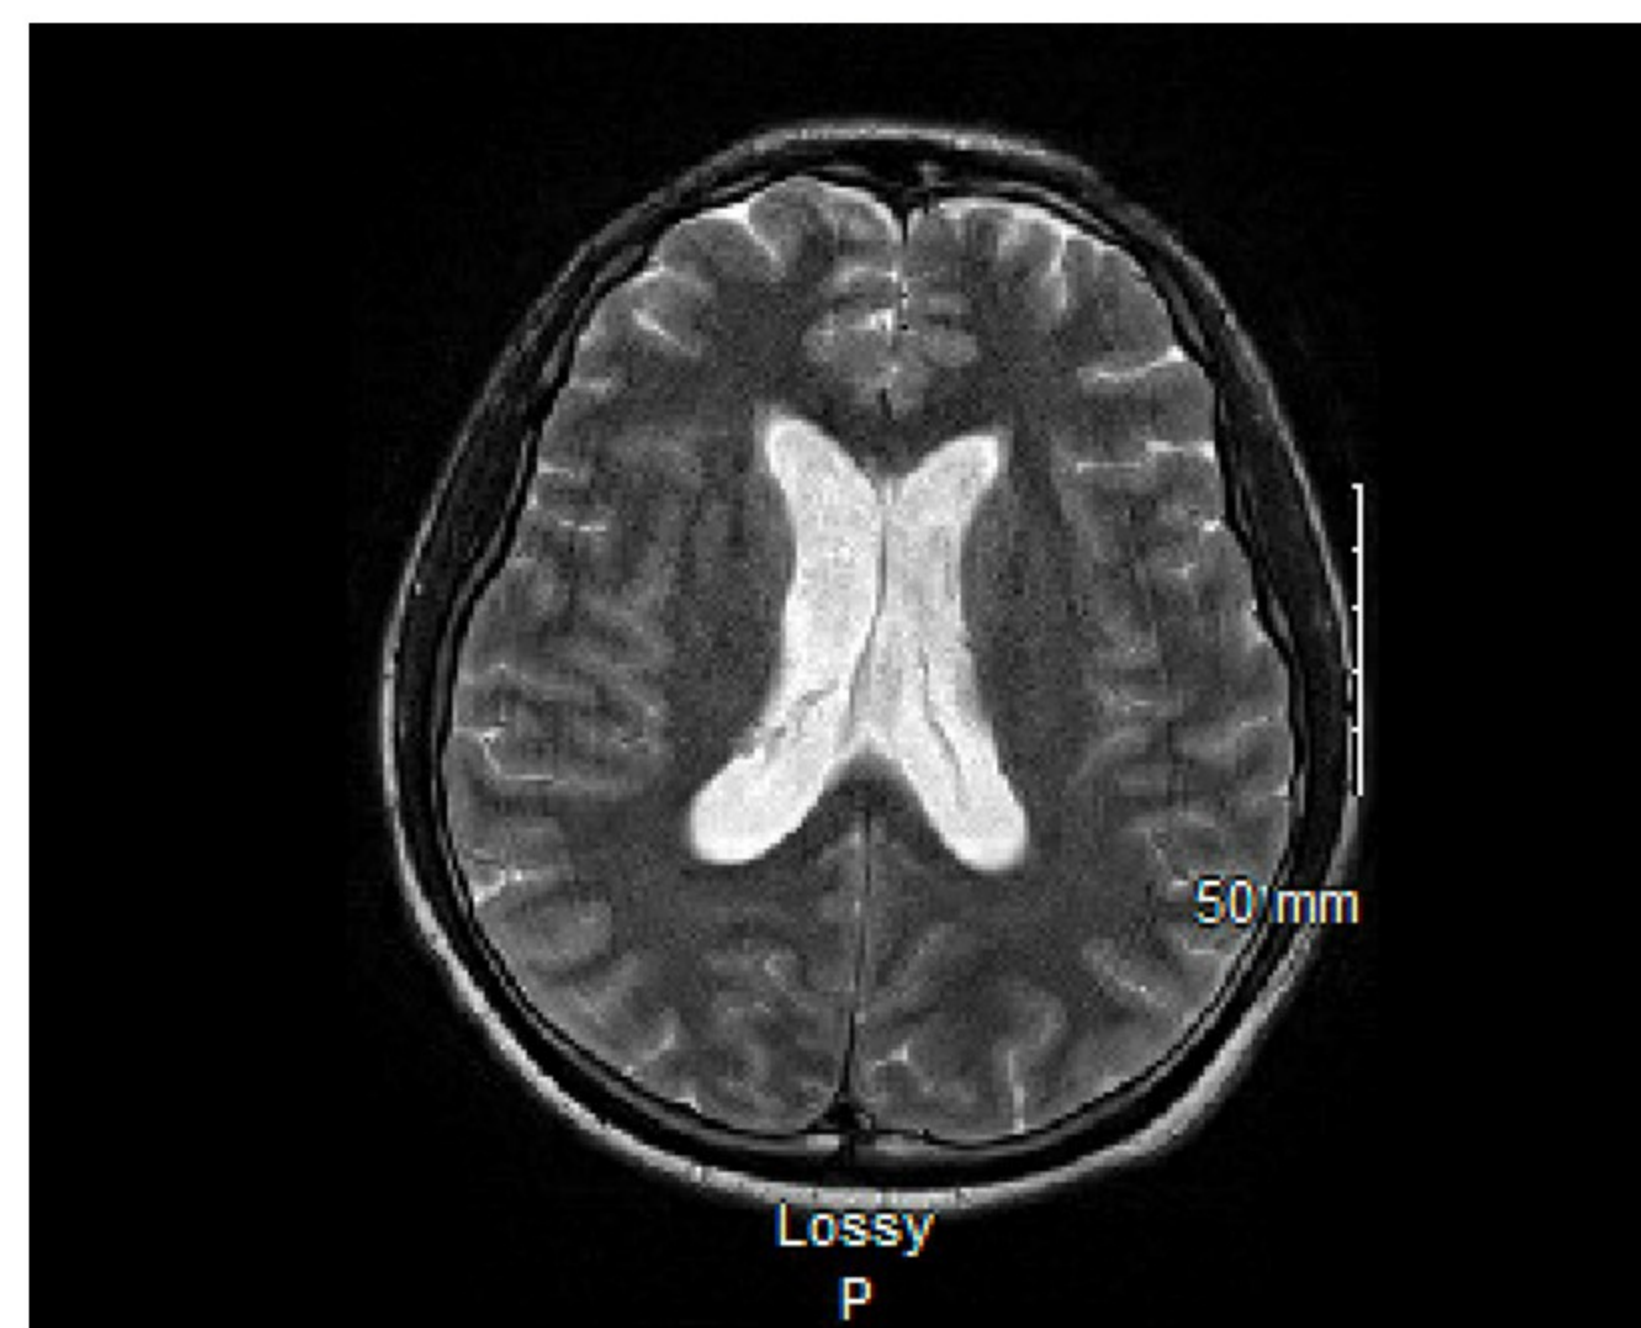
MRI Brain with and without contrast showing diffuse leptomeningeal enhancement and hydrocephalus.
